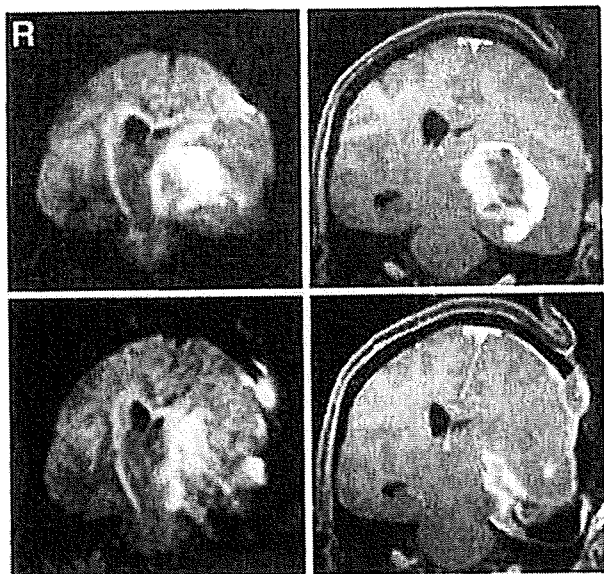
Coronal intraoperative diffusion-weighted (left column) and postcontrast T_1 -weighted magnetic resonance images (right column) before (upper row) and after resection of the left frontotemporal glioblastoma (lower row). Removal of the neoplasm was accompanied by outward displacement (maximum 4.8 mm) of the white matter bundle containing the pyramidal tract. Note that T_1 -weighted images clearly demonstrate the position and size of the tumor, but not the pyramidal tract.
